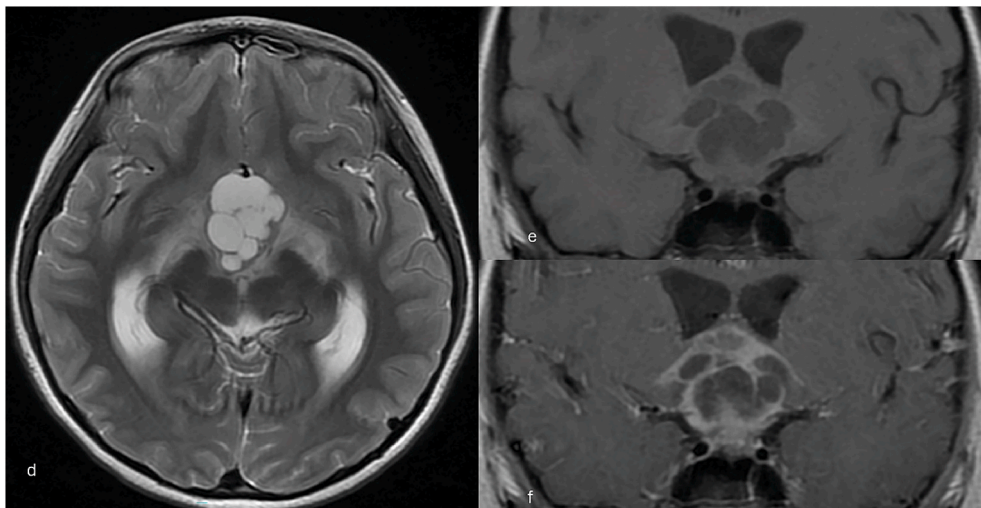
A 13-year-old female with a germinoma in the suprasellar region exhibits a lesion with multiple large high signal intensity components on the T2-weighted image (d), which display low T1 signal intensity (e) and only marginally enhance on the T1 post-contrast image (f), indicating cystic components. All the cystic components are greater than 1 cm, so we categorize this tumor as a tumor with big cysts.
